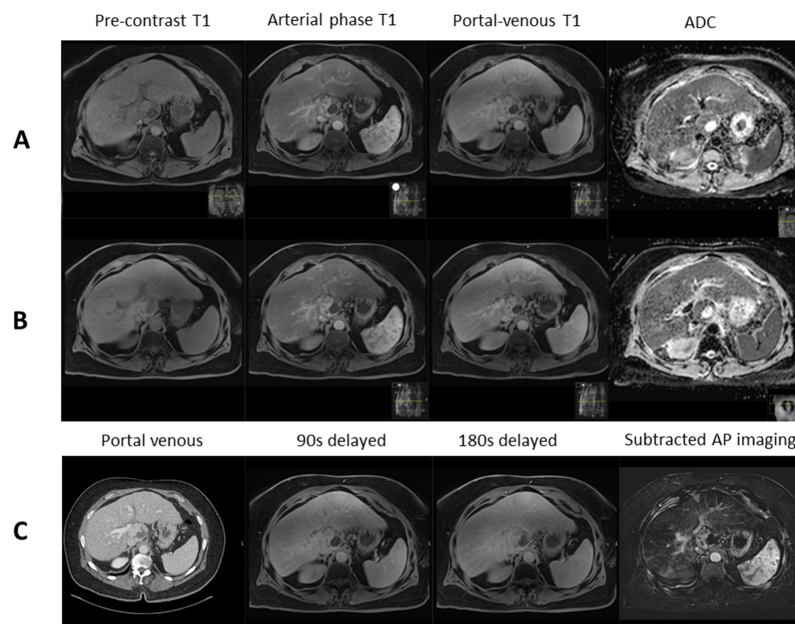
Contrast-enhanced magnetic resonance imaging demonstrating: pre-treatment caudate lobe hepatocellular carcinoma with restricted diffusion ($ADC\ 1101 \times 10^{-6}$) (A); post-stereotactic body radiotherapy scan showing no treatment response with restricted diffusion ($ADC\ 917 \times 10^{-6}$) (B); and corresponding contrast-enhanced computed tomography and delayed imaging with hepatobiliary contrast agent showing perfusional changes around the tumour with no response (C). ADC: apparent diffusion coefficient
